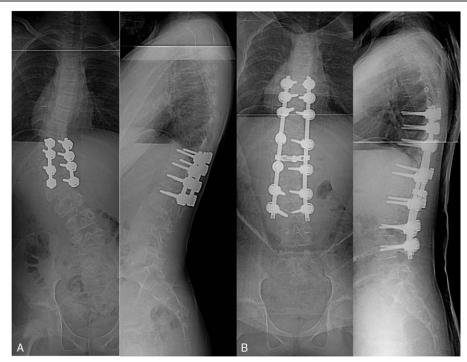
(A) Seven-year follow-up radiographs after the initial surgery showing that the main scoliotic curve deteriorated to 54° and distal compensatory curve has progressed to 33°. (B) Immediate postoperative radiograph after revision surgery with posterior vertebral column resection showing that the main curve of scoliosis improved to 14° with distal compensatory curve of 2°.
